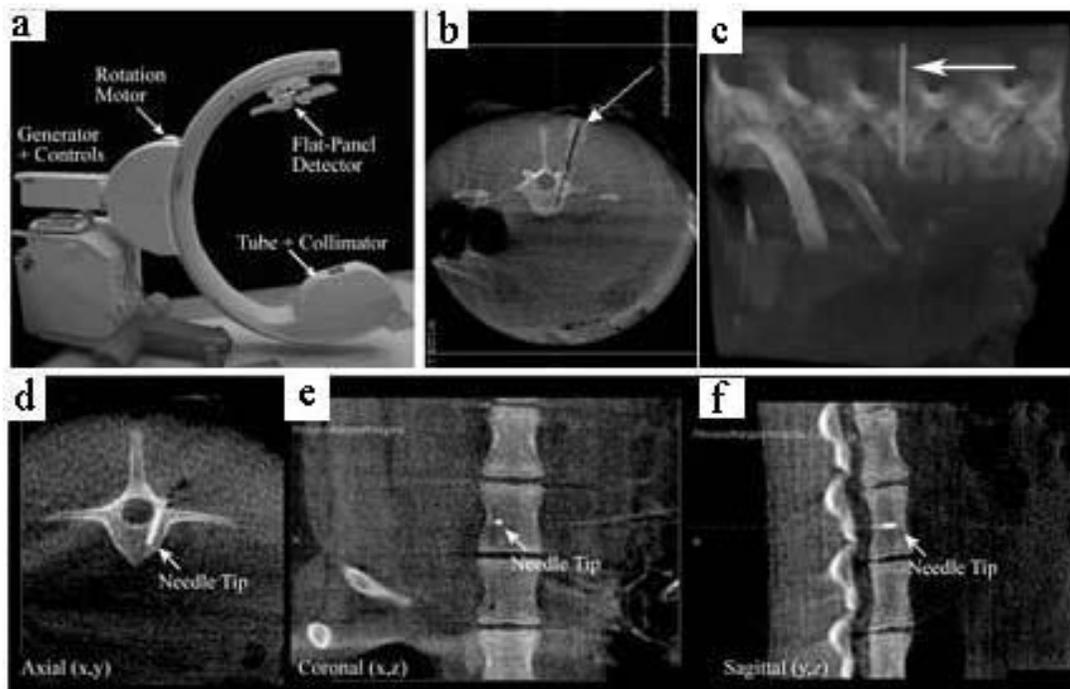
(a) Cone beam CT unit with C-arm and flat panel detector. (b) Axial reconstruction showing transpedicular placement of the delivery fiber held in place using a custom-designed bone screw device (arrow). (c) 3D reconstruction showing a cannula in vertebral body of L1. (d-f) alternate, 2D views of inserted cannula.
